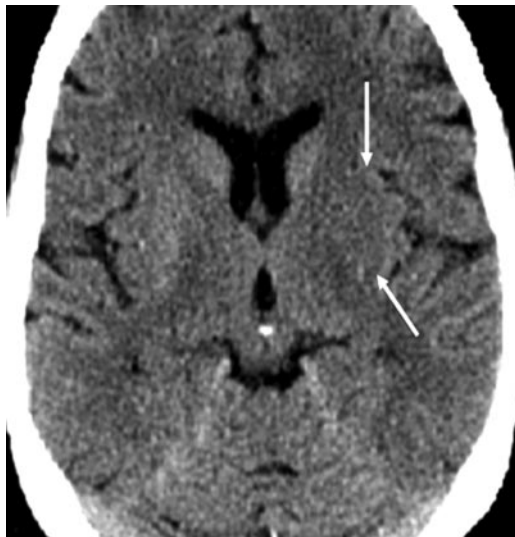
Axial unenhanced CT image obtained in a 53-year-old man (same patient as in Fig 2a) shows hypoattenuation and obscuration of the left lentiform nucleus (arrows), which, because of acute ischemia in the lenticulostriate distribution, appears abnormal in comparison with the right lentiform nucleus.
